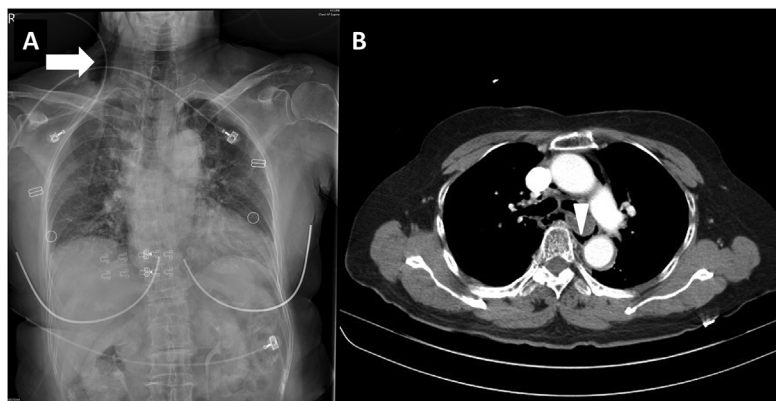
(A) Chest radiography demonstrates subcutaneous emphysema (arrow) and pneumomediastinum. (B) Computed tomography shows disruption of the esophageal wall with peri-esophageal food-fluid and air collection (arrowhead).
